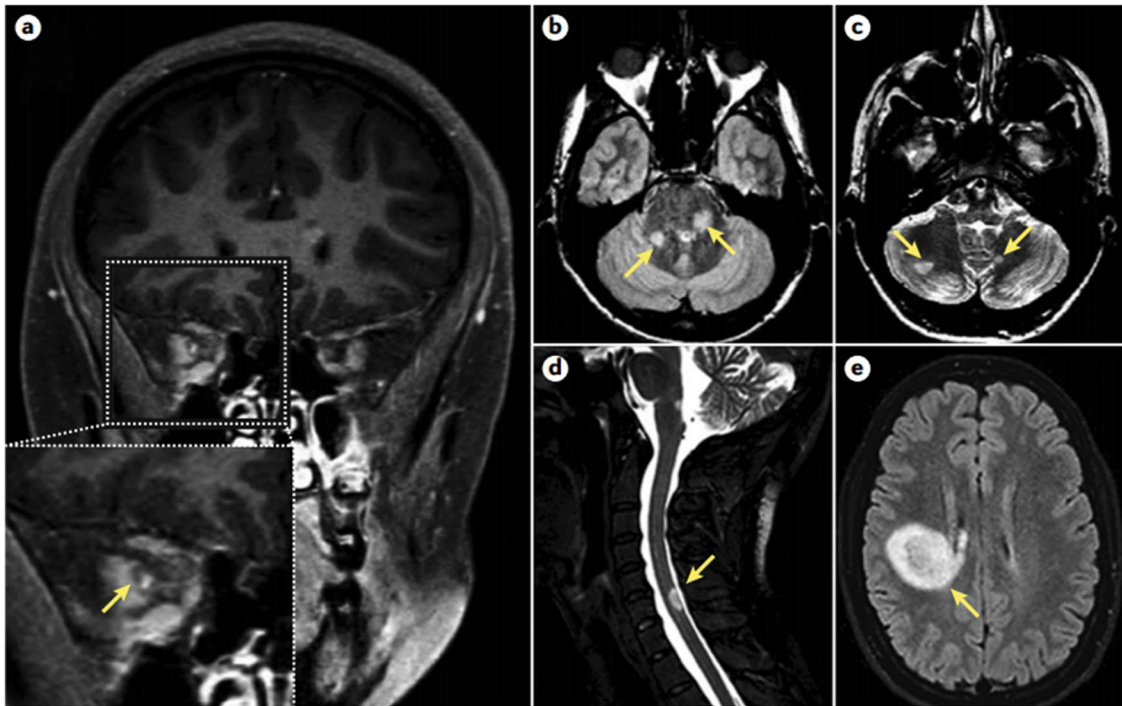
3T MRI sequences from five patients with CIS suggestive of MS, within 5 days from clinical onset, are shown. Focal lesions (arrows) can be observed in the right optic nerve in a patient with acute optic neuritis (a); the left pons and the right middle cerebellar peduncle in a patient with diplopia (b); the cerebellar hemispheres in a patient with vertigo (c); the cervical spinal cord in a patient with paresthesia and Lhermitte sign (d); and the left cerebral hemisphere in a patient with right sensorimotor hemisindrome (e).
